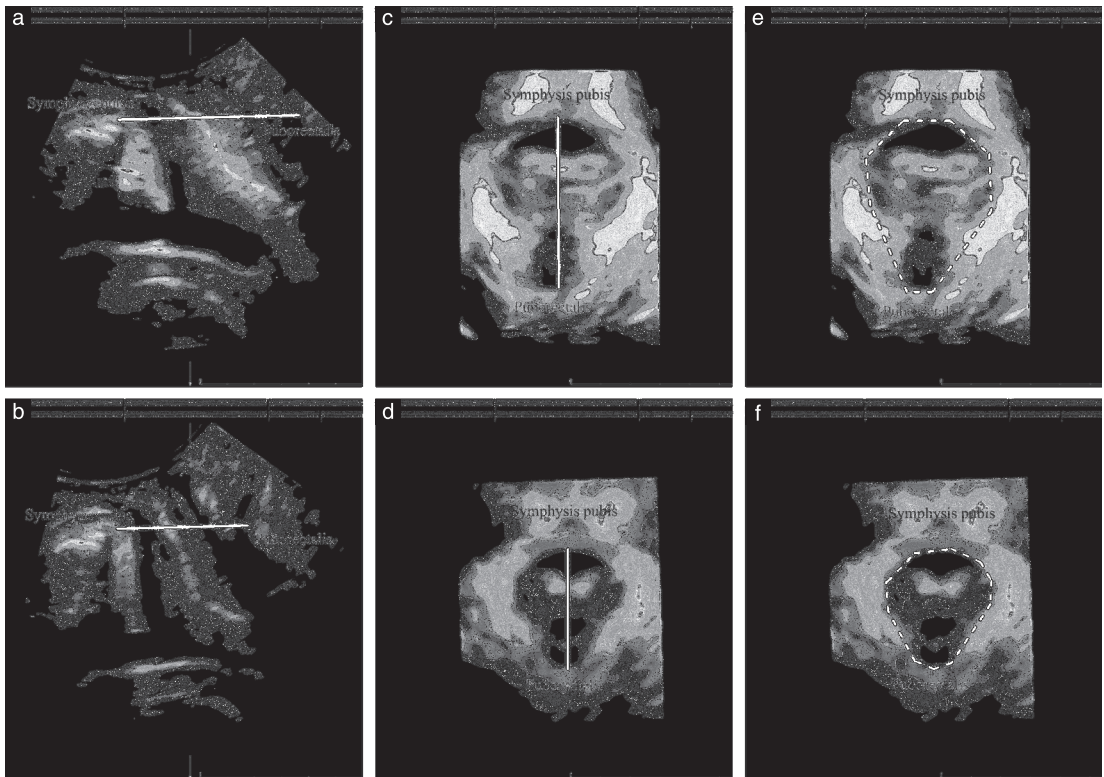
2D (a,b) and 3D (c–f) ultrasound images of pelvic floor, showing measurements of levator hiatal anteroposterior diameter (—) from inferior margin of pubic symphysis to medial margin of puborectalis muscle at rest (a,c) and on contraction (b,d), and levator hiatal area (---) at rest (e) and on contraction (f).
